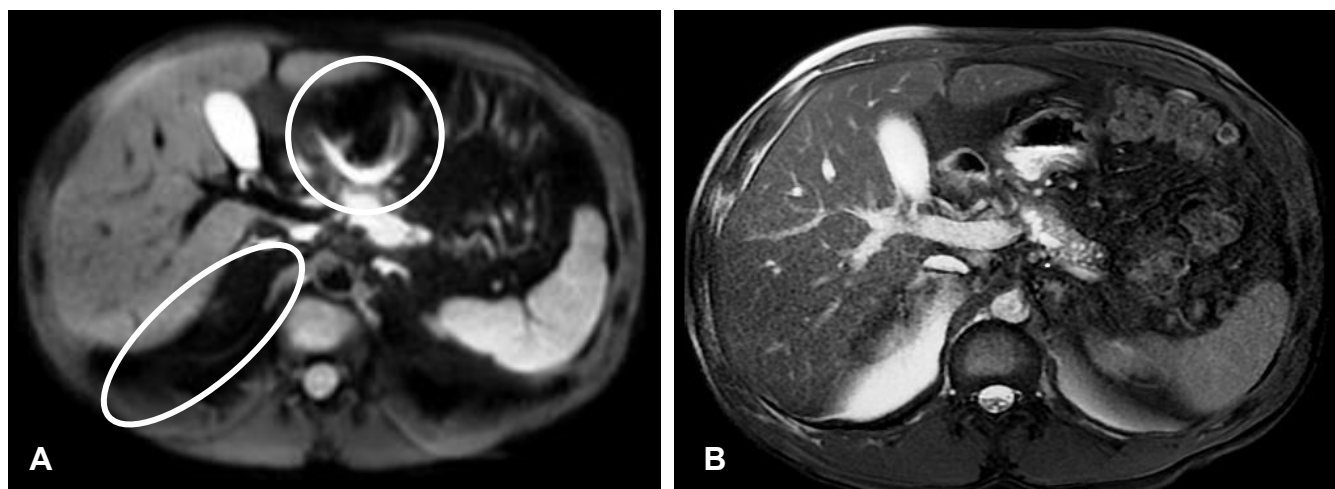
Axial liver images of a 43-year-old male. (A) Single-shot echo planar imaging DWI with a b -value of 200. (B) Same location using FIESTA. Note the amount of image distortion in the DWI image (circles). This distortion, referred to as geometric distortion, is an example of the sensitivity of EPI to magnetic susceptibility effects such as tissue-air interfaces, compact bone-tissue interfaces, or susceptibility effects caused by the presence of metal, for example, orthopaedic implants. In EPI and gradient-echo imaging techniques, these areas of magnetic susceptibility cause high degrees of dephasing and image “bending” or distortion. Nevertheless, DWI of the liver can be highly sensitive to liver pathologies and motion-free due to the ultrafast imaging speed of EPI.
